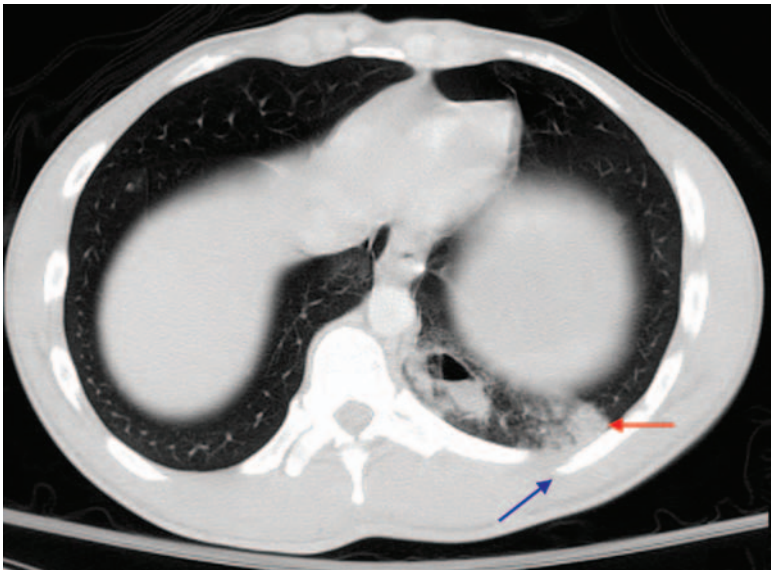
CT chest with rib fractures (yellow arrow) and pulmonary contusion (red arrows)
